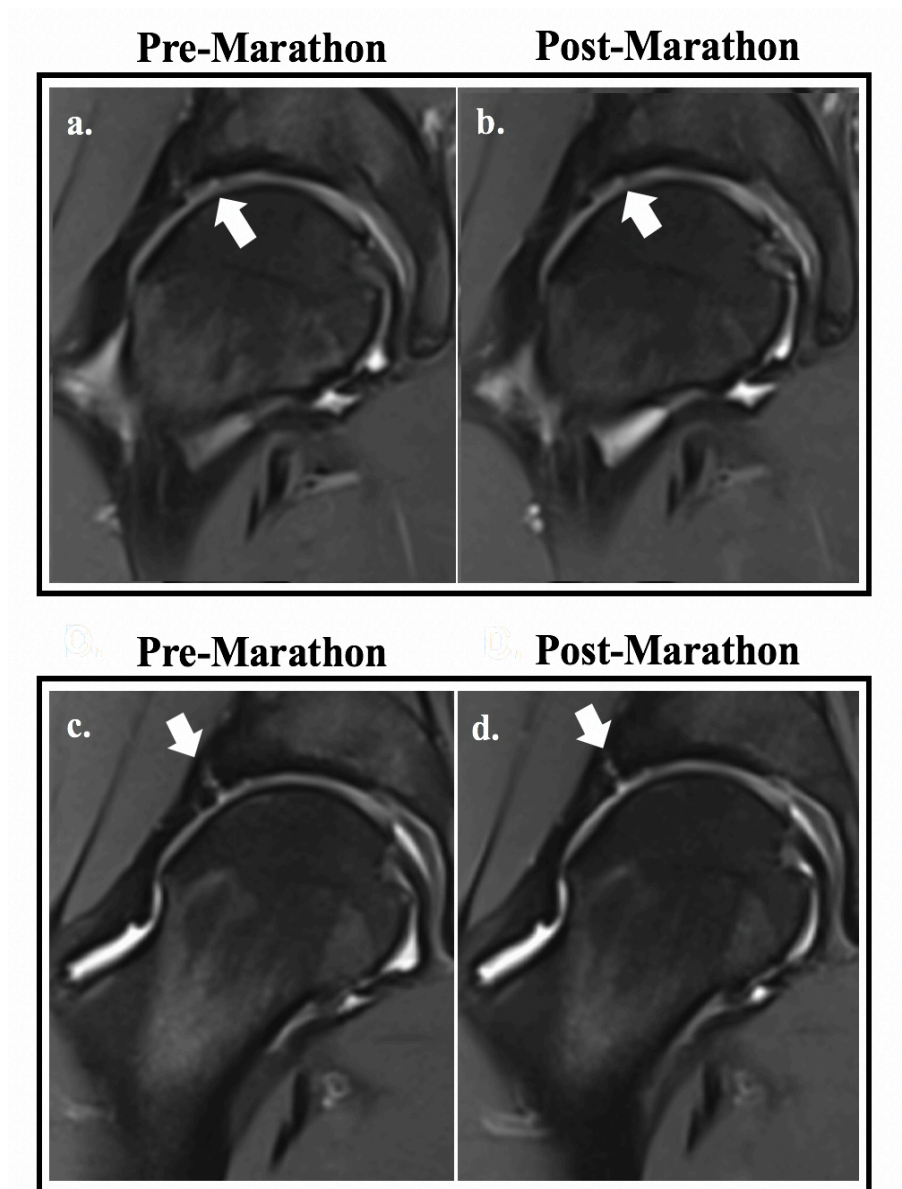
Coronal Dixon MR images of 2 participants showing damage before the marathon and no worsening after the marathon. Participant 1 (a - pre-marathon; b – post-marathon) had a full thickness acetabular cartilage defect (arrowed). Participant 2 (c - pre-marathon; d – post-marathon) had a labrocartilage separation (arrowed). SHOMRI grading system was used; SHOMRI, Scoring hip osteoarthritis with MRI.
